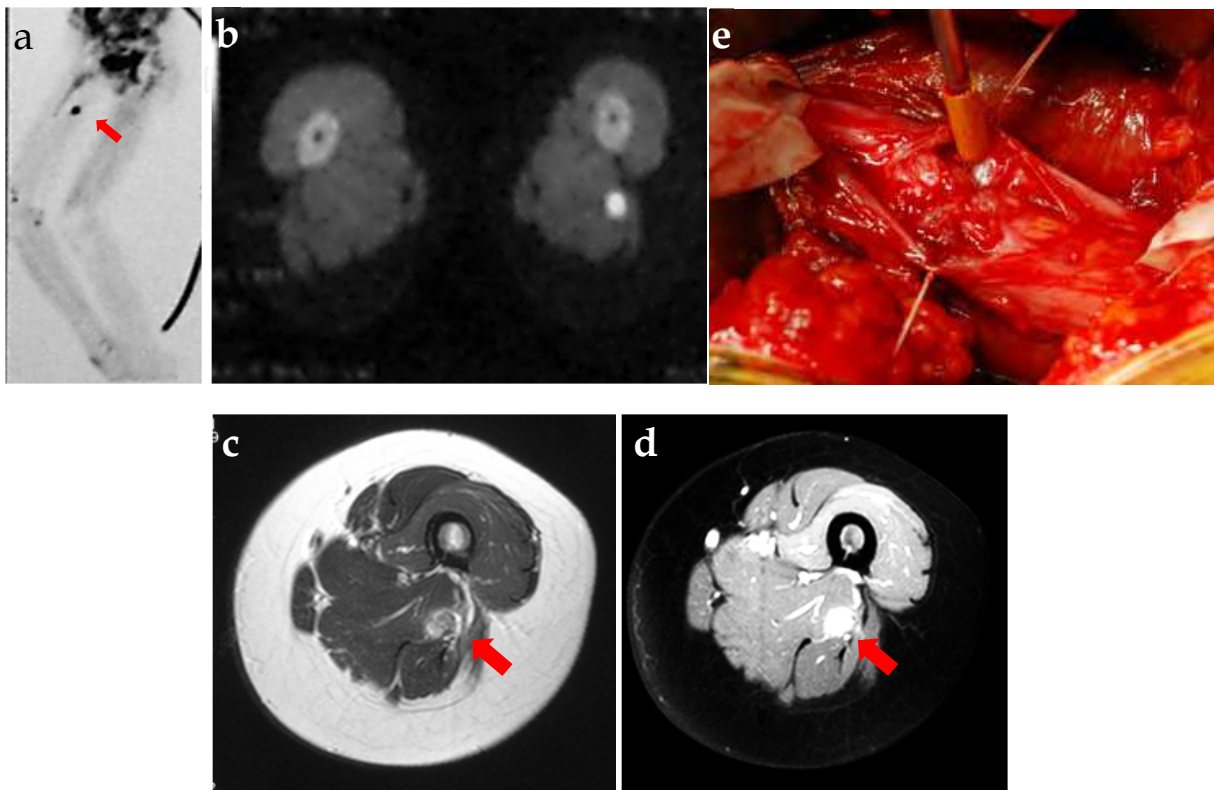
Nodular fasciitis in the sciatic nerve detected by ^{18}F FDG-PET (a,b). T2-weighted MRI (c) and Gd enhanced MRI (d) demonstrated the mass in the right hamstring. After fascicular dissection, the lesion under fascicular of sciatic nerve is disclosed entrapping the perineurium of sciatic nerve(e).
